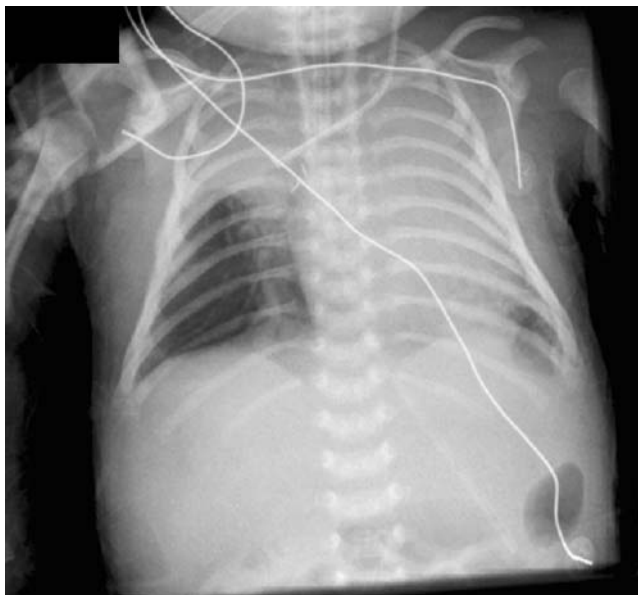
Chest radiograph after the Blalock-Taussig shunt operation shows poor aeration of the left lung and collapse of the right upper lung
